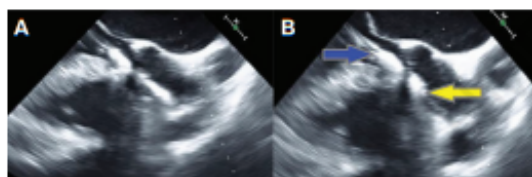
Implantation of balloon-expandable valve in a systematic two-step approach that included: (A) the positioning step; and (B) the full deployment step under transesophageal echocardiography and radiographic guidance. Arrows indicate the working length of the Sapien 3 balloon, which was inflated at 4 atm.
